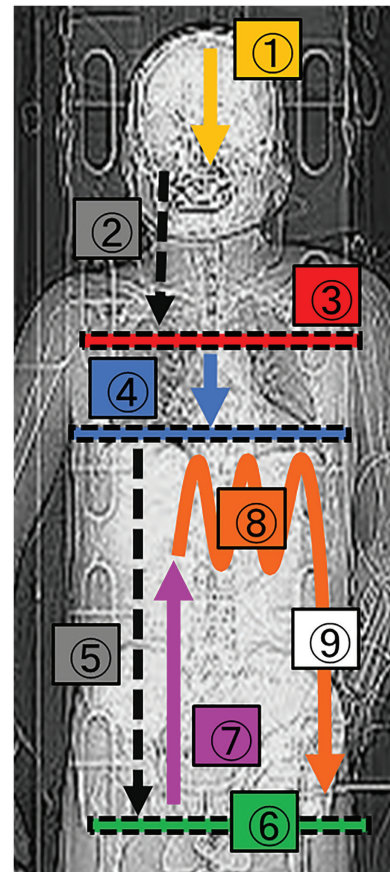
The reading order of the CT images during the focused assessment with computed tomography (FACT) for trauma protocol. Figures 2 to 5 explain details and examples.
